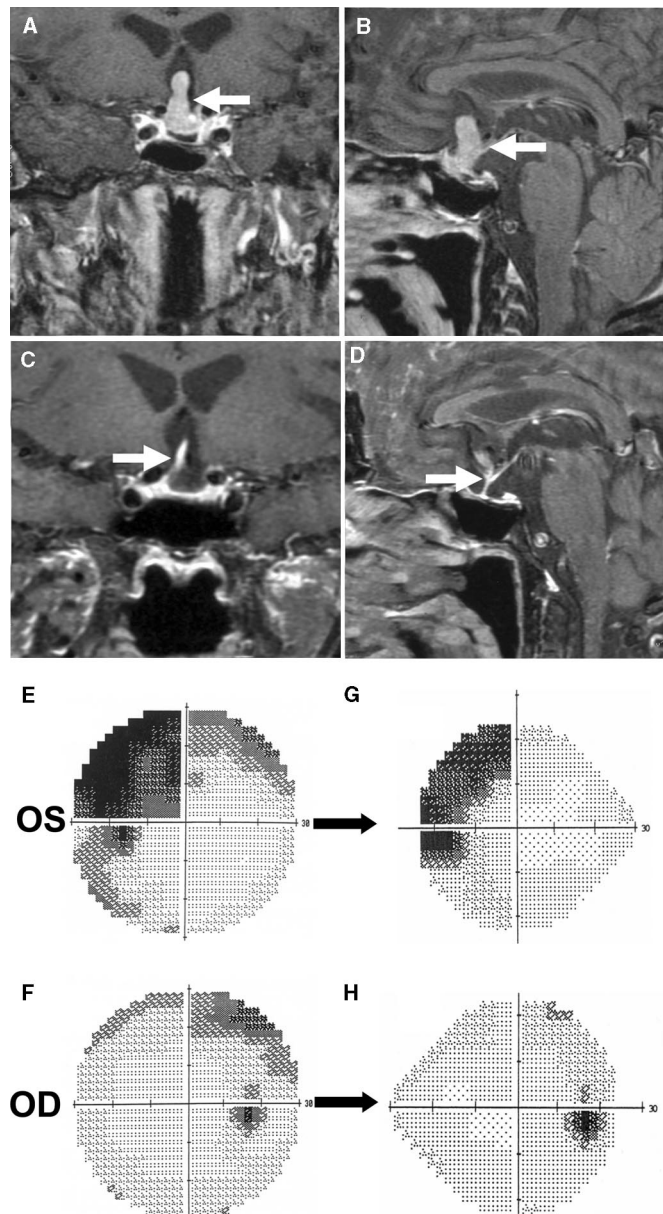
Coronal (A and C) and sagittal (B and D) T-1 contrast MRI scans demonstrating a recurrent, nonsecreting pituitary adenoma (arrows) in a 67-year-old man just before (A and B) and 52 months after (C and D) multisession CyberKnife radiosurgery using a prescription dose of 24 Gy at the 85th percentile isodose line in five sessions. Bilateral visual field examination immediately before (E and F) and 53 months after (G and H) radiosurgery.
